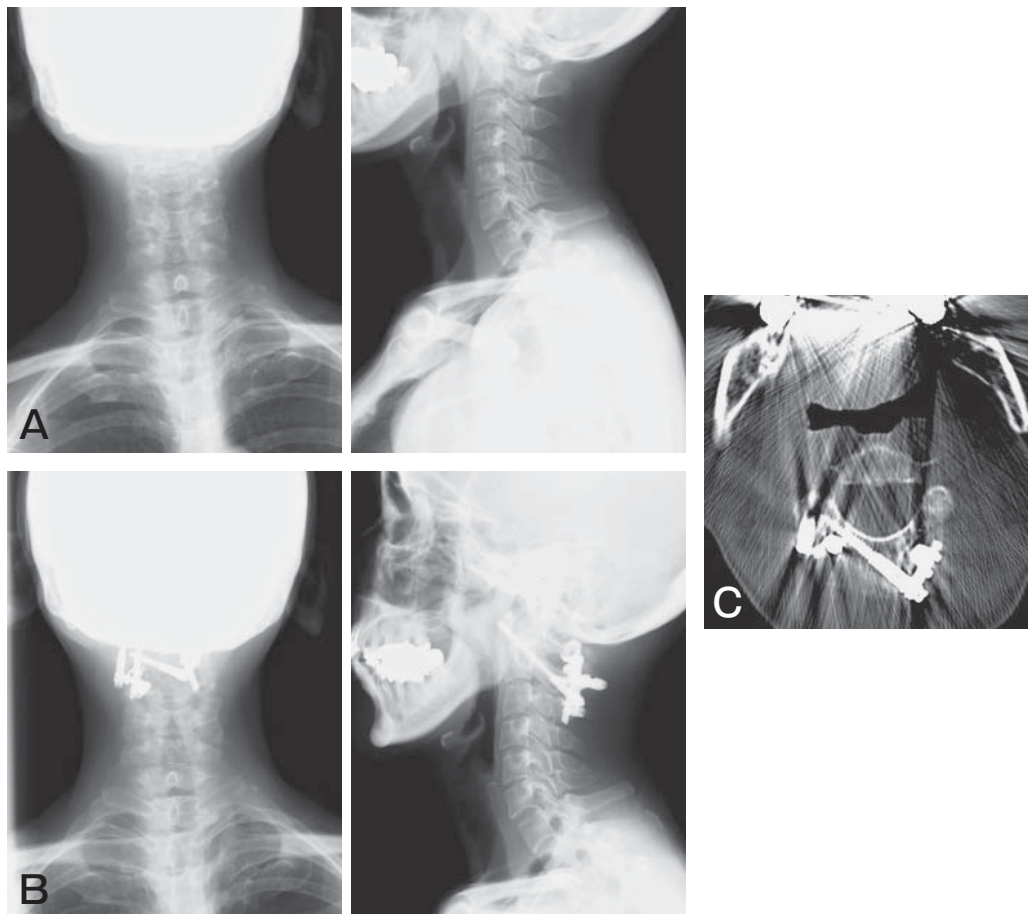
Roentgenogram and CT. A, Preoperative roentgenogram: A 56-year-old woman with anterior atlantoaxial subluxation (AAS); B, Postoperative roentgenogram; C, Postoperative CT: During the atlantoaxial fixation by the Magerl method, massive bleeding was observed during insertion of a trans-articular screw, so we used laminar screws instead.
